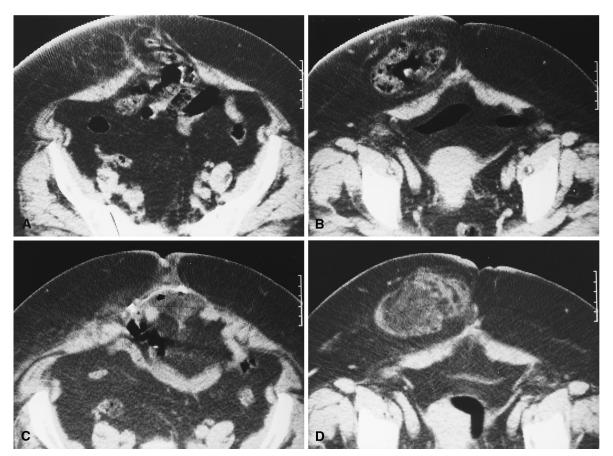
A, B CT of the postsurgical ventral hernia at different levels. C, D After laparoscopic repair, the mesh is easily visualized (*arrow*); the hernia sac was not resected and does not contain bowel loops. CT findings did not change after 30 days.
